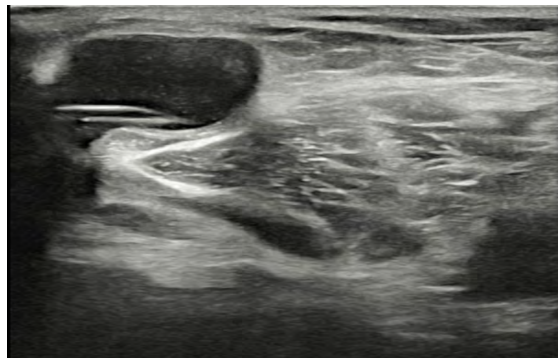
Ultrasonography of knee joint effusion in suprapatellar recess.
